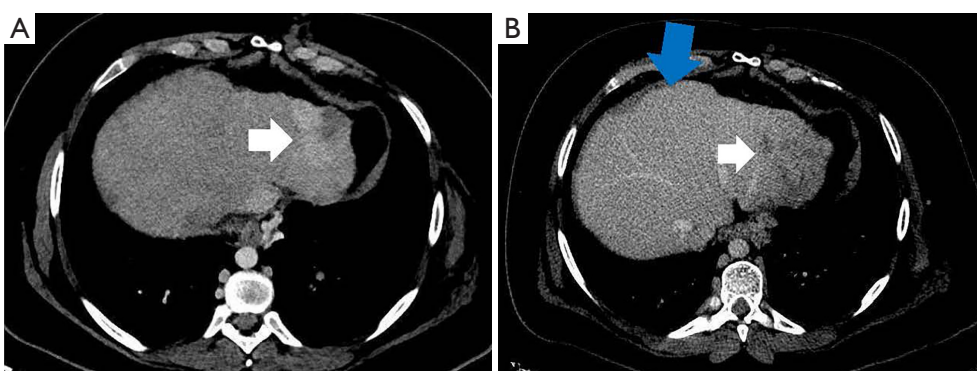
CT abdomen and pelvis. (A) Arterial phase. Partly hypervascular, heterogeneously enhancing mass in hepatic segment two (white arrow). (B) Portal venous phase. Hepatic contour nodularity, consistent with cirrhosis (blue arrow). Partial washout of the mass in keeping with pathological diagnosis of hepatocellular carcinoma-cholangiocarcinoma (white arrow).
